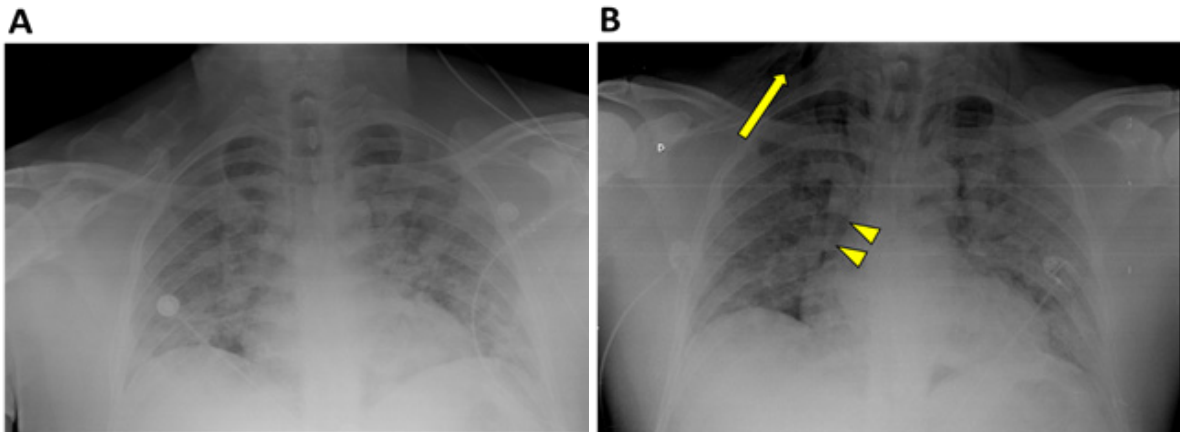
Chest X-ray performed on admission, which found only extensive bilateral pulmonary opacities.
